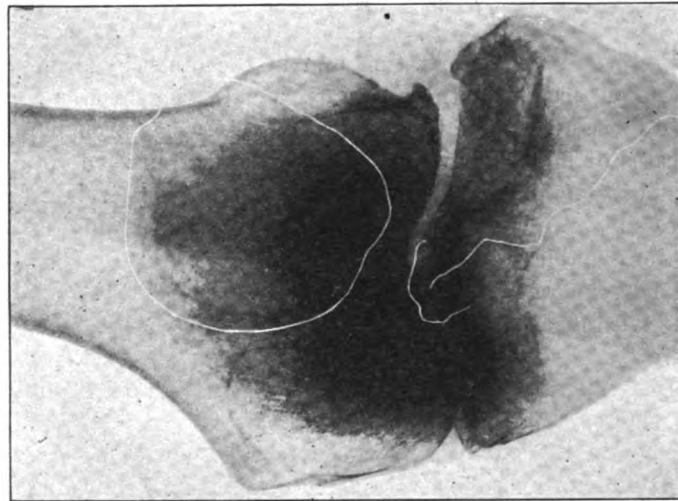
Note widening of tibial tuberosities. Line of fracture involving spine and both tubercles of it. Dropping of articular surface below the line of the head of the fibula. Compare spine of tibia with that in x-ray No. 1.
